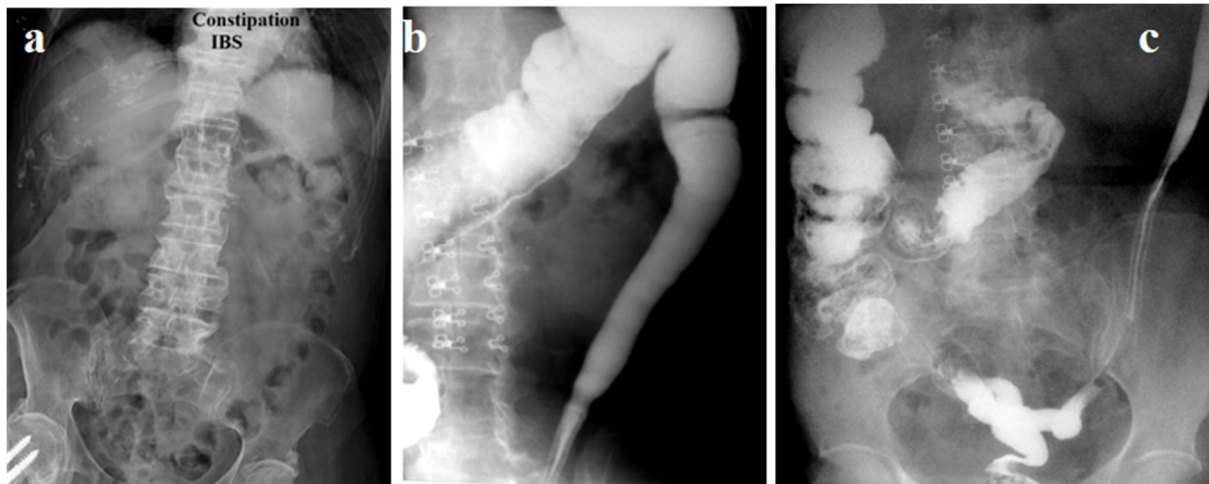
Radiographs of a 62-year-old woman with severe IBS, taken prior to a right-sided colostomy. (a) A frontal radiograph shows a symptom of a rosary in the descending colon. The right half of the colon is also narrowed. (b) During a barium enema, a sharply narrowed descending bowel is visible. (c) After emptying, a narrowed sigmoid colon, a spastic descending colon, and a narrowed right half of the colon are seen.
